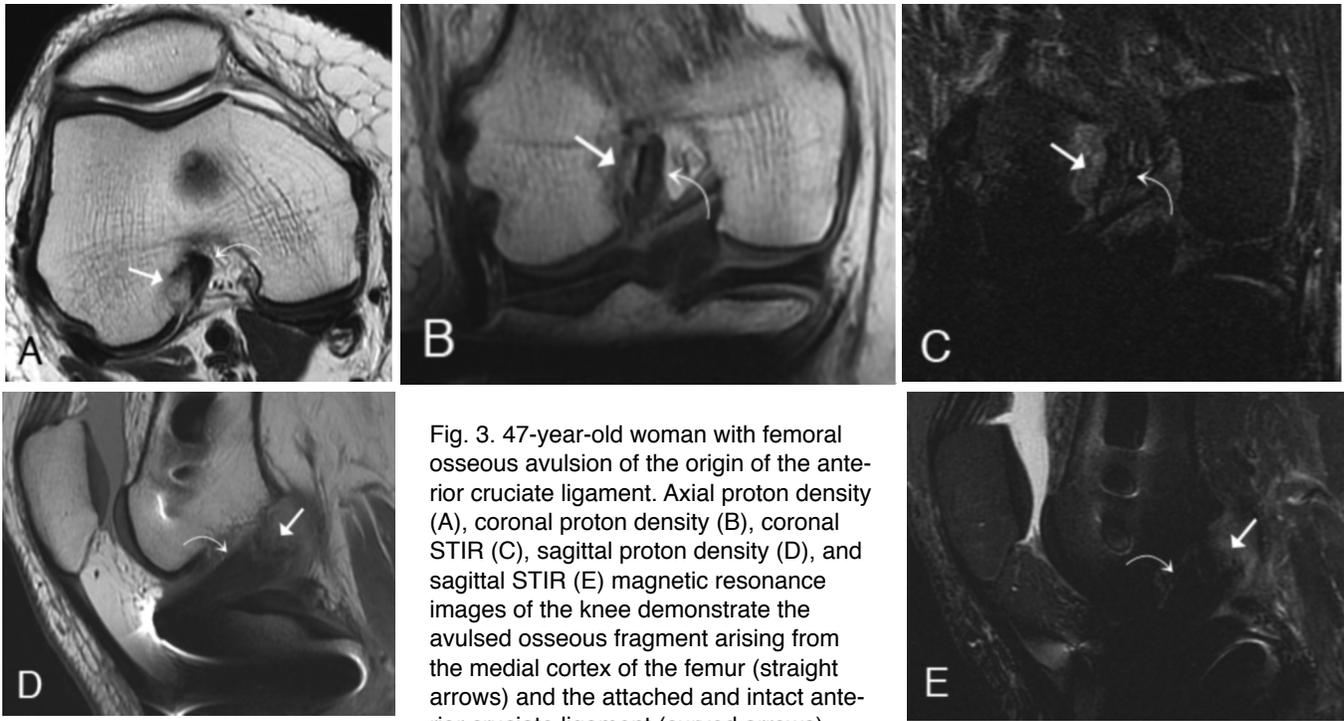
47-year-old woman with femoral osseous avulsion of the origin of the anterior cruciate ligament. Axial proton density (A), coronal proton density (B), coronal STIR (C), sagittal proton density (D), and sagittal STIR (E) magnetic resonance images of the knee demonstrate the avulsed osseous fragment arising from the medial cortex of the femur (straight arrows) and the attached and intact anterior cruciate ligament (curved arrows).
